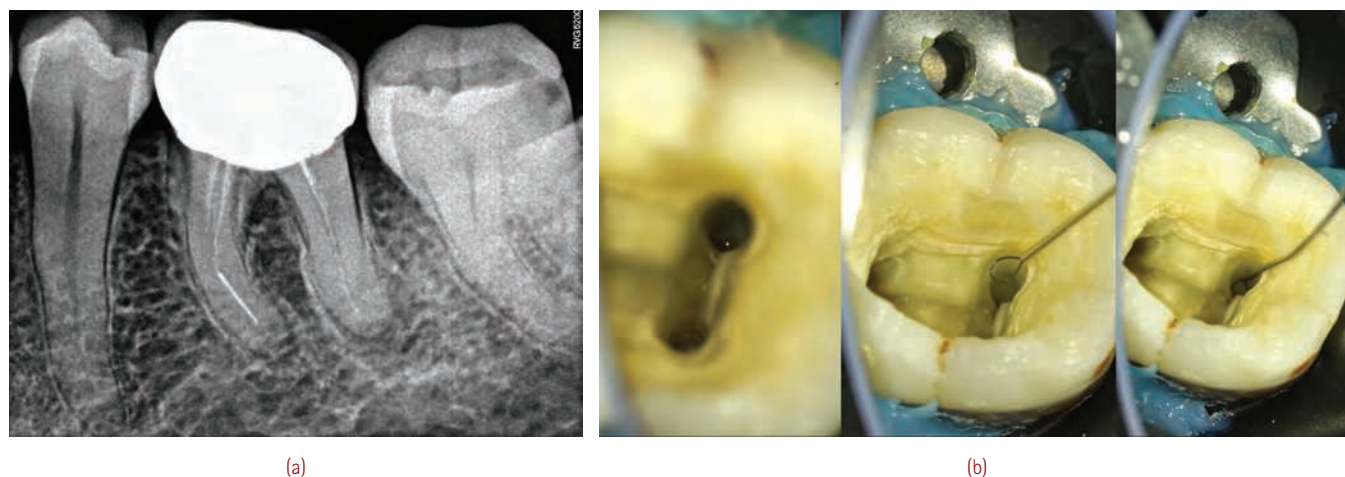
(a) Preoperative x-ray showing separated instrument beyond the level of curvature in the apical third of the mesiobuccal canal of a lower first molar (b) Use of a BTR pen loop to engage the coronal third of the fragment after creating a channel path. (continued)
